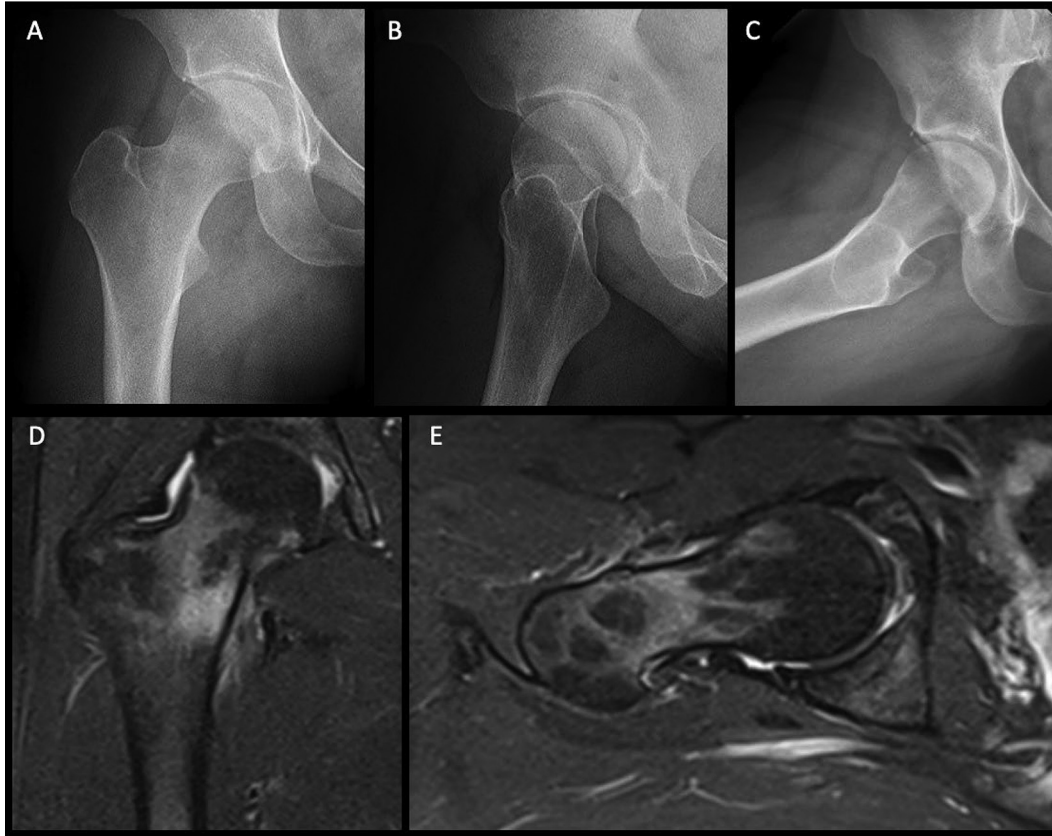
Imaging of a patient with a right-sided FNSF. Radiographs of a right femur: (A) anteroposterior view, (B) external rotation view, and (C) lateral view. T2-weighted fat-saturated MRI of a right femur: (D) coronal view and (E) axial view. An initial trial of nonoperative management failed in this patient, with an MRI demonstrating a femoral neck stress injury, with a nondisplaced fracture line on radiographs. FNSF, femoral neck stress fracture; MRI, magnetic resonance imaging.
